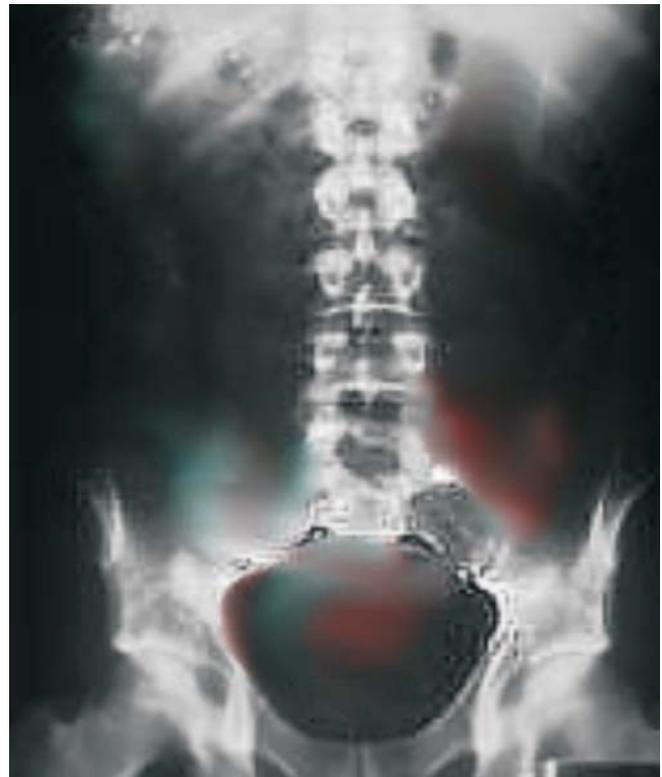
X-ray abdomen after 2 days of hospitalisation
